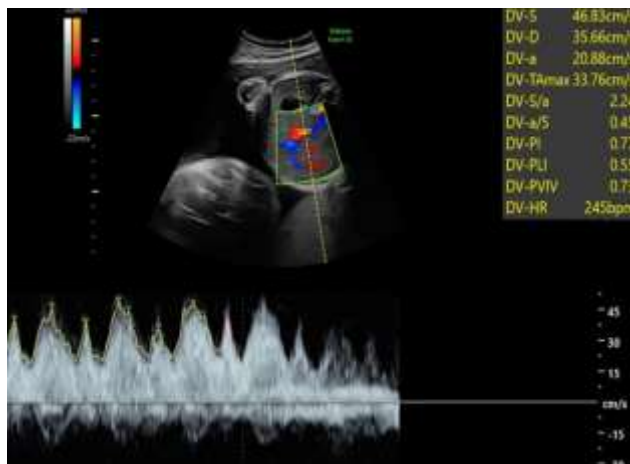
Ductus venosus Doppler for twin 1.
